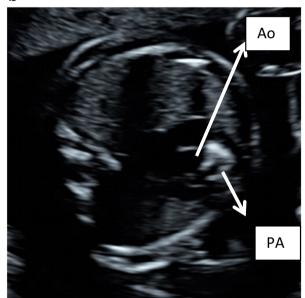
a: Fetal Echocardiogram in the 3vessel outlet view (3VV) demonstrating the superior vena cava (SVC), Aortic arch (Ao) and Pulmonary trunk (PA). Note that the wall of the pulmonary trunk is bright (evidence of possible calcification) as compared to the aortic arch and SVC.
